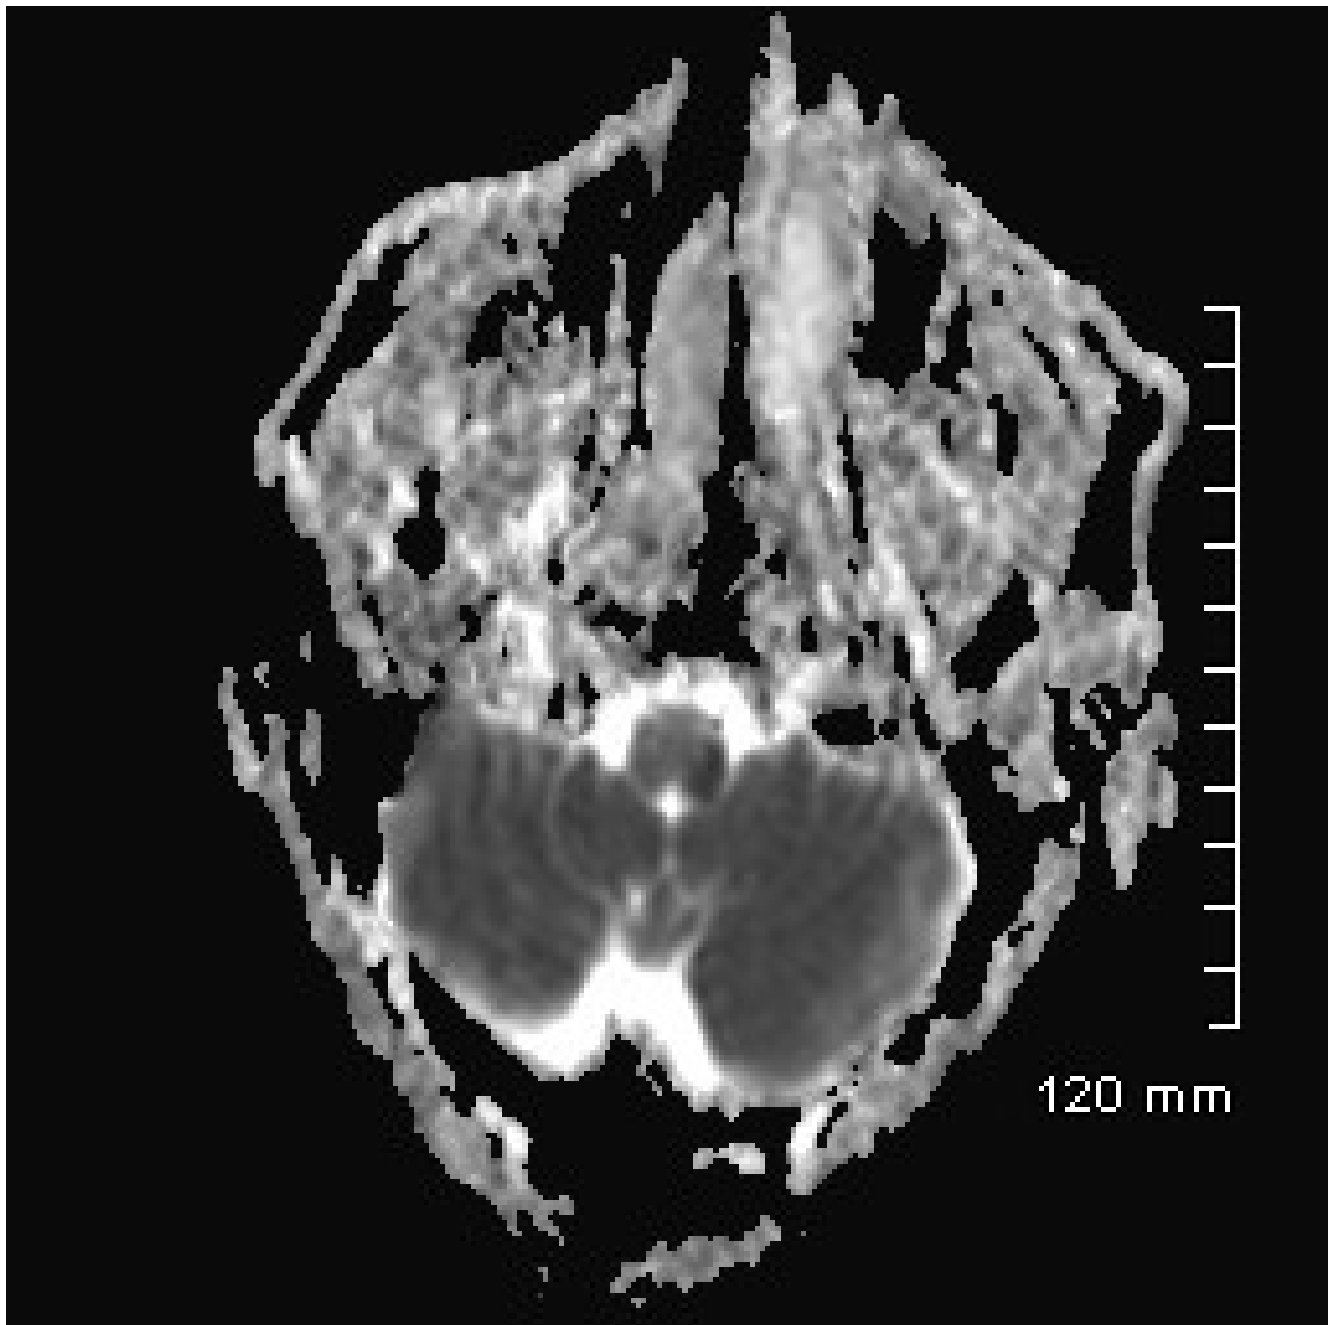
on MRI for Case Study #2
